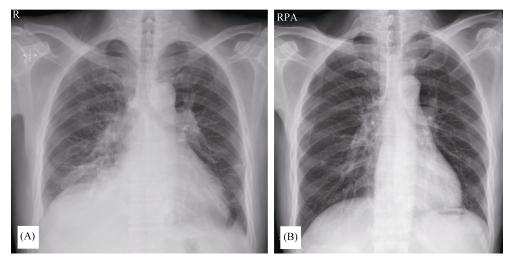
Chest X-ray showing cardiomegaly with right pleural effusion (A) and decreased cardiac chamber two weeks later (B).
